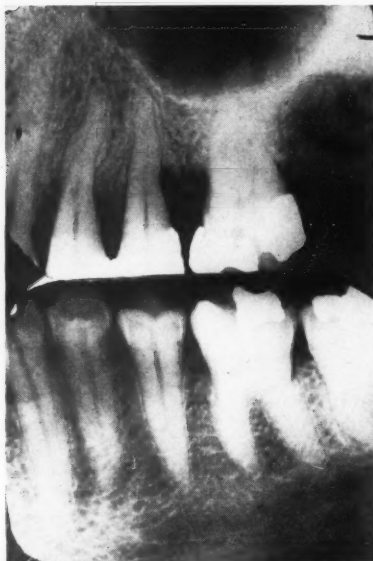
Roentgenograms show extent of loss in bone attachment. Clinically, second bicuspid is loose. There is marked separation between molar and second bicuspid.
